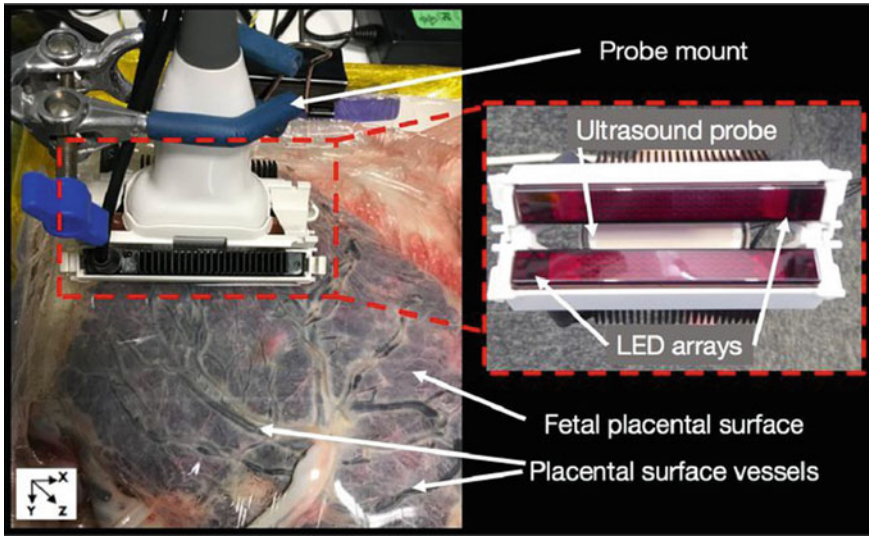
Experimental setup to image a human placenta. A clamp was used to mount the ultrasound probe with the light emitting diode (LED) arrays to the linear motorized stage. The placenta was coated with ultrasound gel, covered with cling film, and placed inside a water-filled container [Reprinted with permission from 43]
